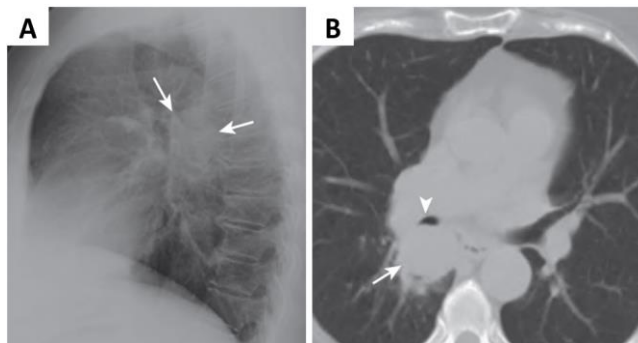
A. Lateral chest radiograph showing an abnormality (mass) in the hilar region, confirmed by B., an axial chest CAT scan, and later determined as being a bronchogenic carcinoma, from Gotway et al. (2016).
